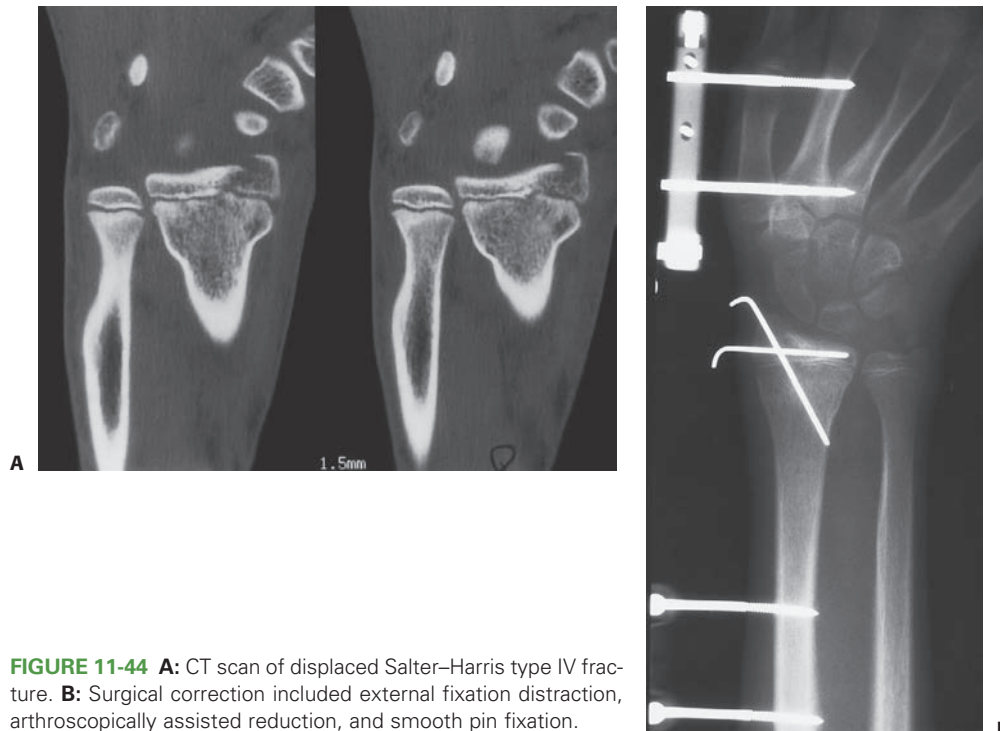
A: CT scan of displaced Salter–Harris type IV fracture. B: Surgical correction included external fixation distraction, arthroscopically assisted reduction, and smooth pin fixation.
